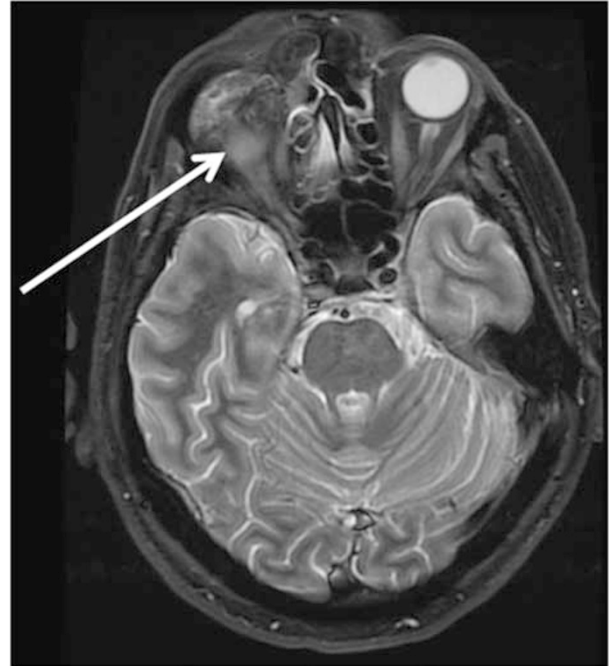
MRI of orbits with gadolinium, 1 month post right enucleation, showing a medpor orbital implant and enhancing soft-tissue mass surrounding the right optic nerve (arrow) in keeping with recurrent lymphoma.
